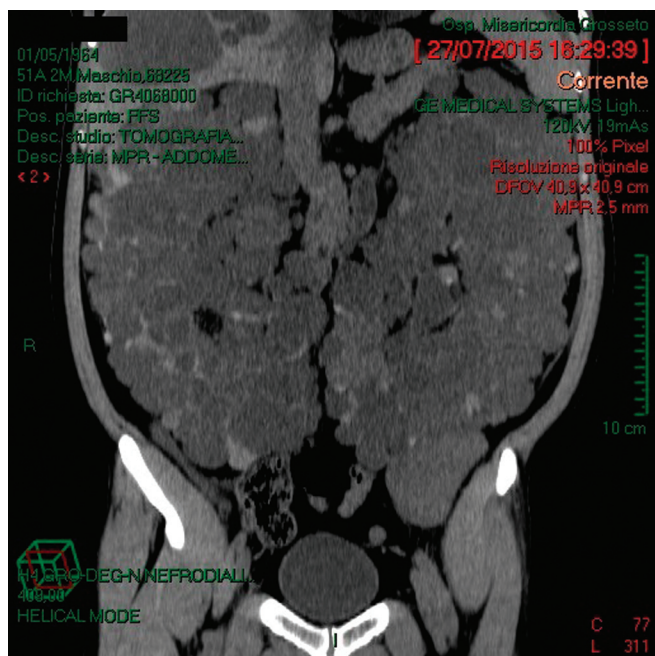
CT scan of massive polycystic kidneys (coronal view).
